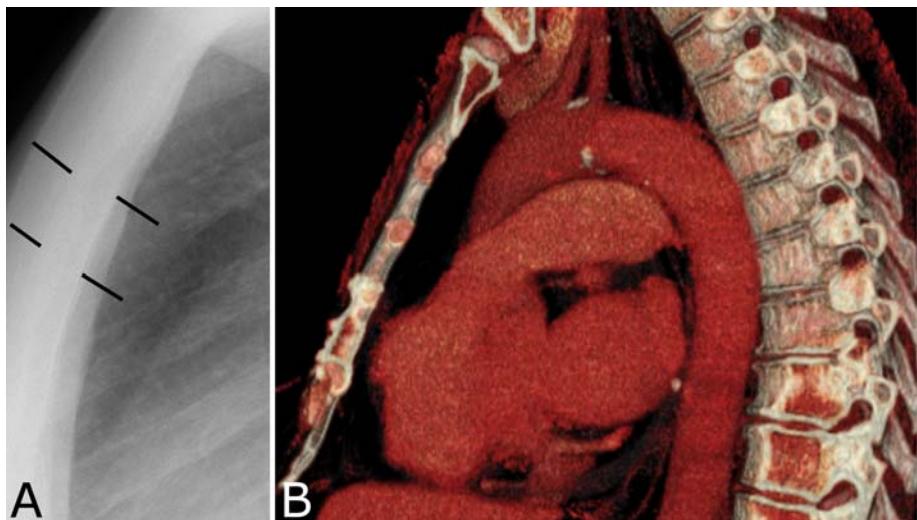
A. Lateral radiograph shows the sternum (black lines) better. *B.* Volume rendered CT image of the sternum showing the sternum as it is seen on the lateral radiograph. Sternal abnormalities are more likely to be visible on the lateral view that on the frontal view because fewer objects overlap the sternum when viewed from the side.
